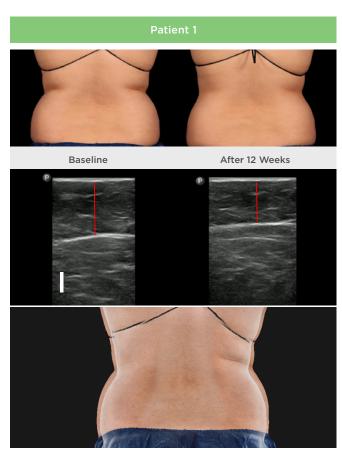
Photos courtesy of Stephen Ronan, M.D. (Top) Patient 1 with before (left) and after (right) photos collected 12 weeks after a single treatment. (Middle) Ultrasound measurements of the right flank indicate a 29% fat thickness reduction. (Bottom) Overlay silhouette photo of the patient before and after treatment. Scale bar 1 cm.
